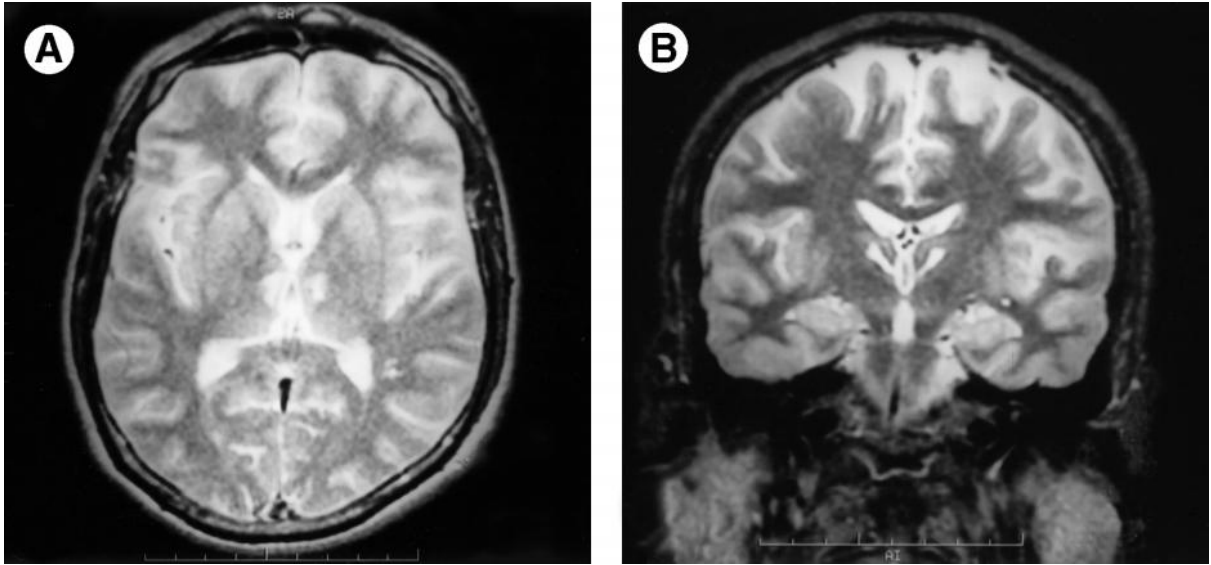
T2-weighted MRI scans showing bilateral paramedian infarction. (A) Axial view. (B) Coronal view.
